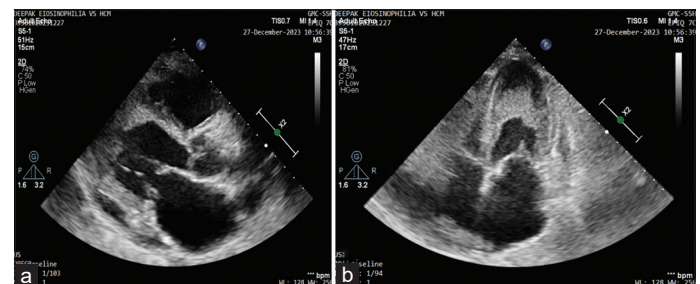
(a) Parasternal view in 2D echocardiography (ECHO) showing enlargement of left atrium and obliteration of left ventricular apex. (b) Apical four chamber view in 2D ECHO showing obliteration of apex and biatrial enlargement with an increased left atrial volume
